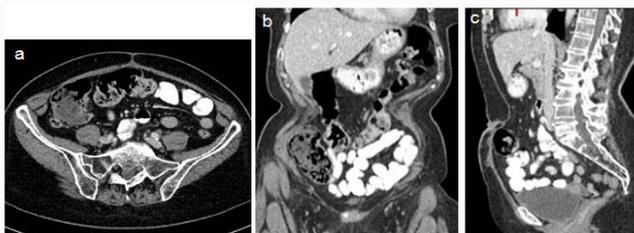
Abdominal enhanced CT showing resolution of the infectious process. a. axial view. b. coronal view. c. sagittal view.
